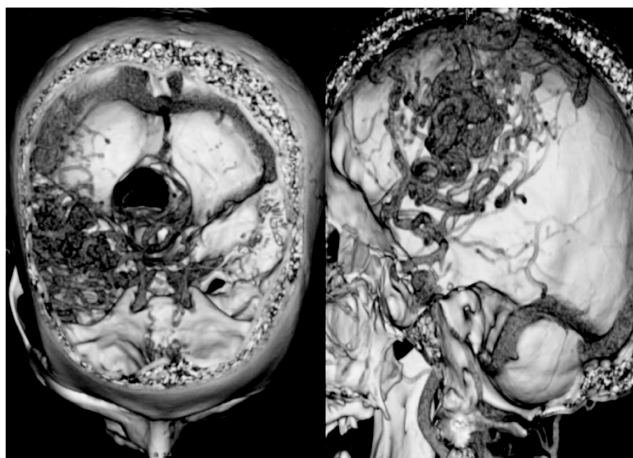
Case (1) 50 years old man presented with headache. CT brain done for him which shown a large cerebral AVM in right parietal region. CTA (volume rendering technique) revealed multiple avidly enhanced dilated primarily intracerebral AVM, which supplied by middle cerebral artery and drained into posterior aspect of the middle part of superior sagittal sinus.
